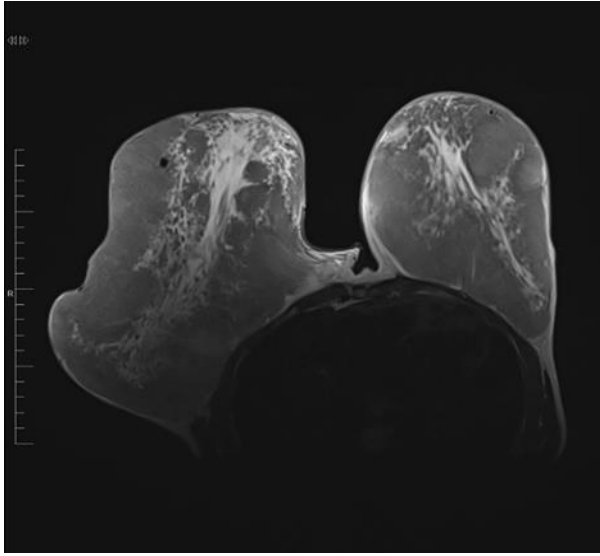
Axial T2 weighted magnetic resonance imaging of the chest shows significant asymmetrical enlargement of the breast, more on the right along with extremely dense fibroglandular tissue bilaterally.
